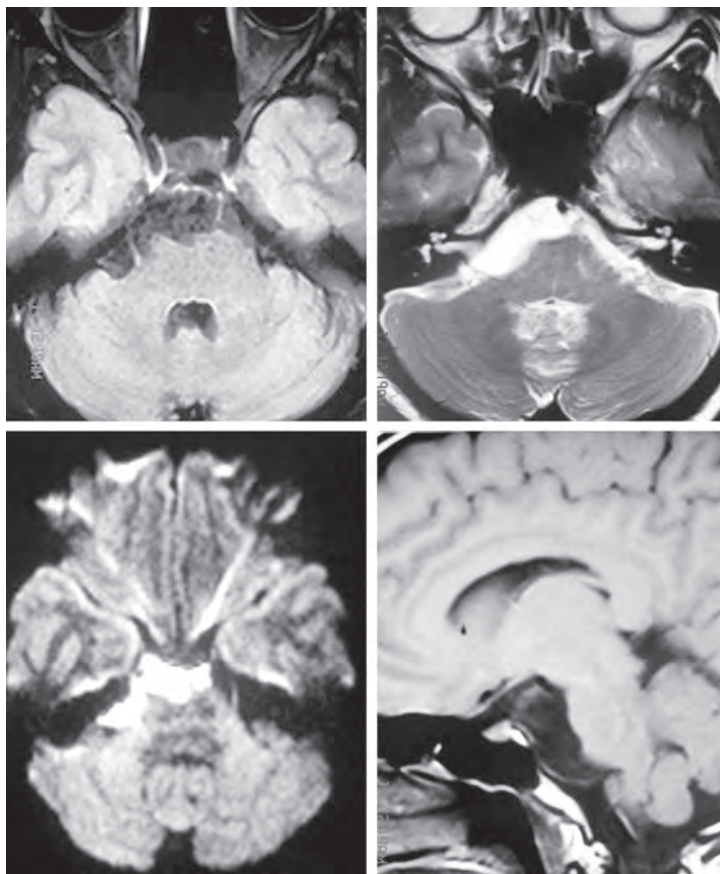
MRI of the brain showing CP angle epidermoid hypointense on T1 and hyperintense on T2 and brilliant hyperintensity with diffusion restriction on diffusion weighted images
